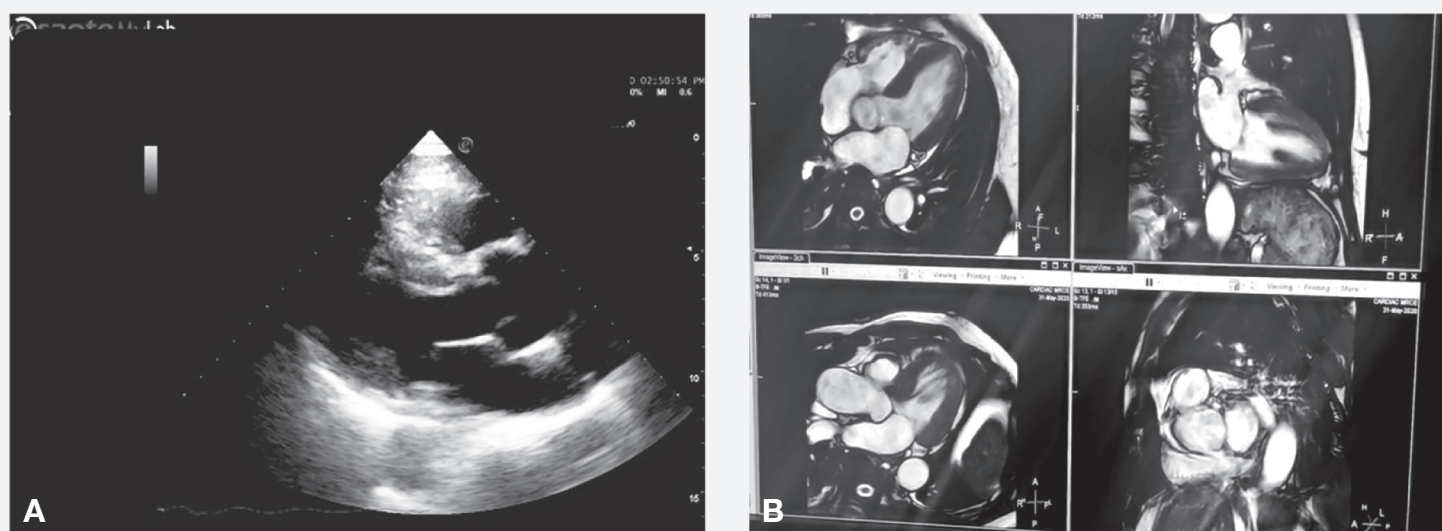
(A) Transthoracic echocardiogram: concentric left ventricular remodeling, normal overall left and right ventricular systolic function, (B) Cardiac magnetic resonance imaging: basal to midseptal left ventricular hypertrophy. Normal biventricular systolic function with no regional wall motion abnormalities. No evidence of myocardial edema, infarction, or fibrosis
